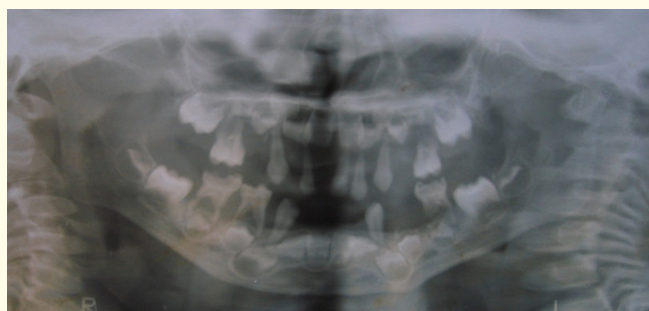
Orthopantomogram at the age of 4 years showing severe periodontal destruction of the remaining teeth and tooth buds of erupting permanent teeth.
